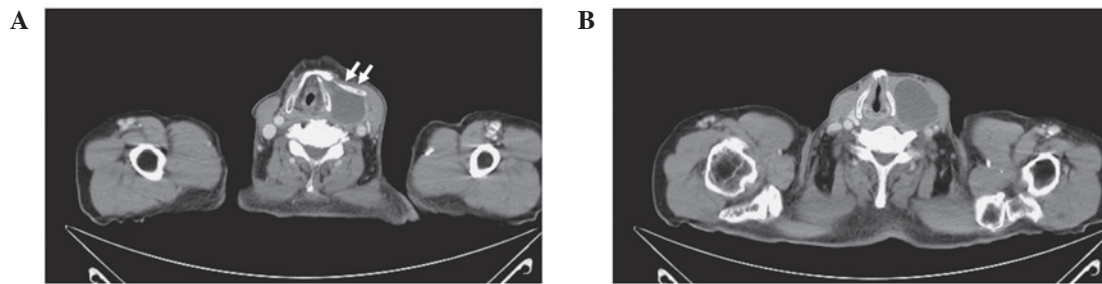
Head and neck computed tomography demonstrated (A) a single hypodense lesion in the left neck, which adhered to an additional hyoid bone (white arrows). (B) The cystic lesion was ~41x34 mm in size, and due to its position, it was considered to have originated from the left lobe of the thyroid gland.
